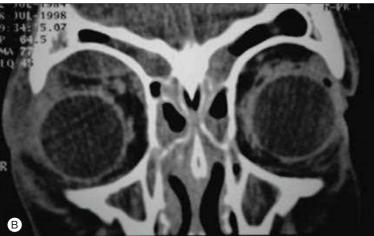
(A) An axial orbital CT scan of an infant with a medial subperiosteal collection adjacent to opacified and underdeveloped ethmoid paranasal sinuses. (B) A coronal CT scan of a 14-year-old male with right orbital cellulitis and a superior subperiosteal abscess. There is pansinusitis, including frontal sinusitis. The location of the abscess and presence of frontal sinusitis are both indications for drainage of the abscess. (Harris GJ. Subperiosteal abscess of the orbit. Age as a factor in the bacteriology and response to treatment. Ophthalmology 1994;101:585–95. Garcia GH, Harris GJ. Criteria for non-surgical management of subperiosteal abscess of the orbit. Ophthalmology 2000;107:1454–8.)
